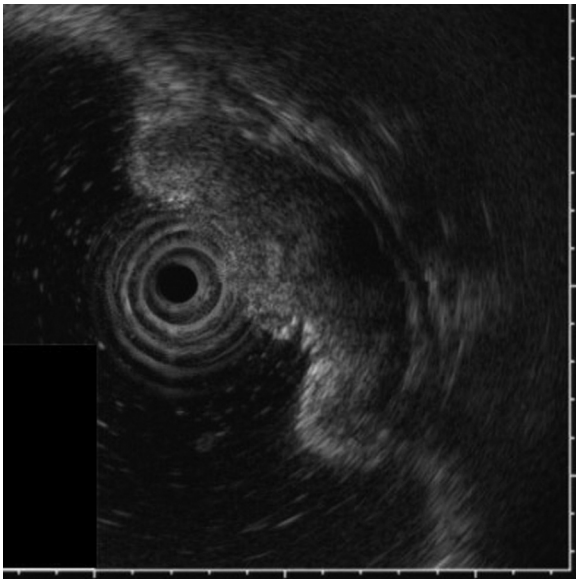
Endoscopic ultrasound finding shows a low echoic mass occupying the upper part of submucosal layer.
